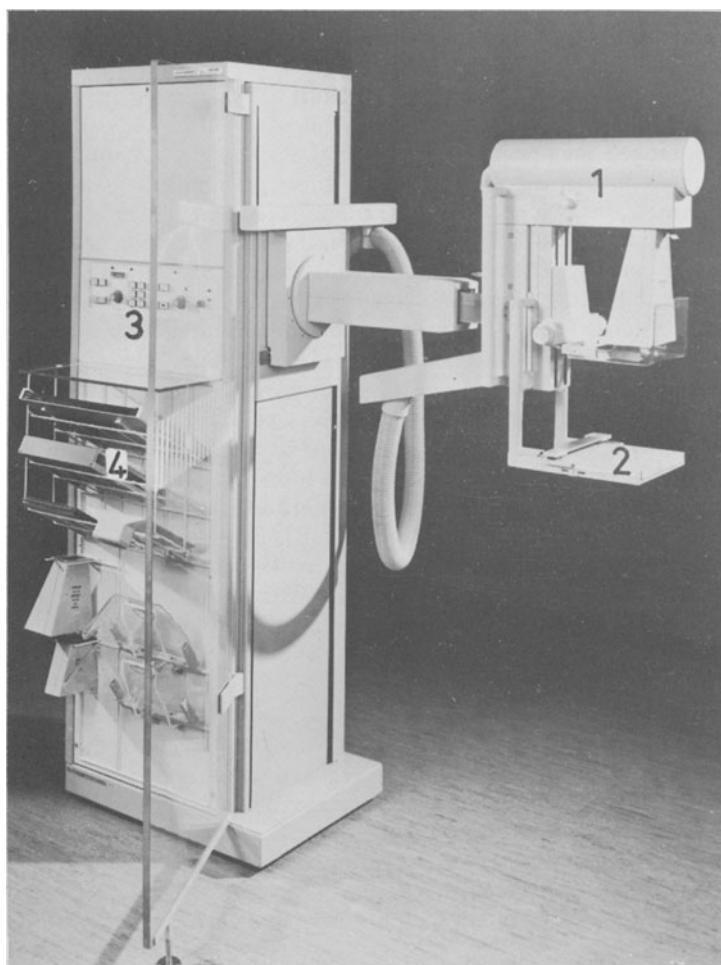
Stand and apparatus for mammography. 1. X-ray tube with collimator and compressor; 2. platform for the positioning of the breast; 3. controls; 4. films, cassettes and accessories.
